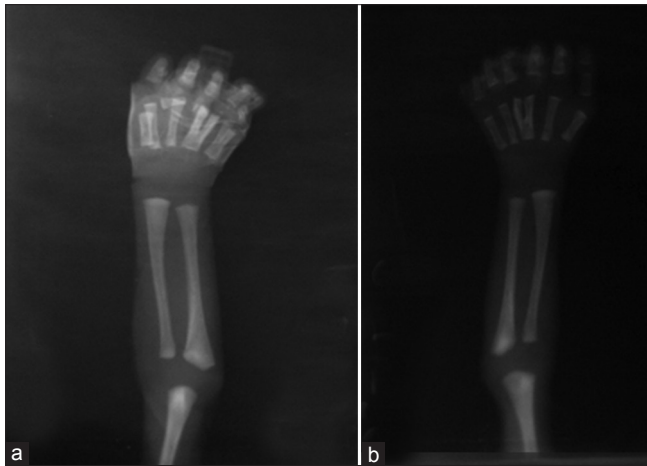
X-ray of both hands showing bifid appearance (Y-shaped) in the 3rd metacarpal on the right hand and the 4th and 5th metacarpals of the left hand with six proximal phalanges seen in both hands
